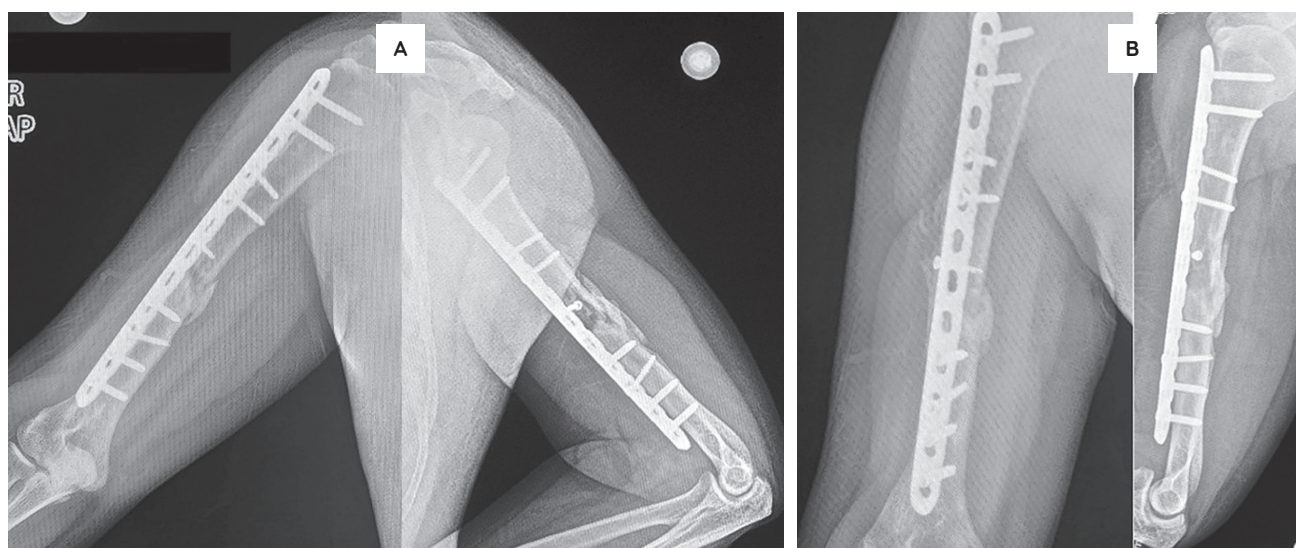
A 31-year-old male diagnosed with oligotrophic nonunion of the humerus 10 months post-operatively. Pre-PRP Radiograph (A) reveals no progression of callus formation. Post-PRP Radiograph after 7 months (B) reveals absence of fracture line and revascularization.
